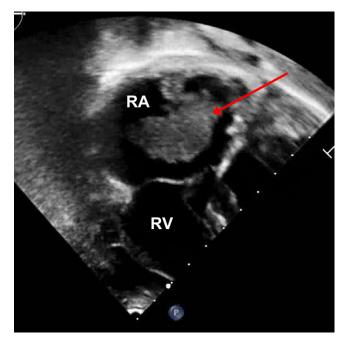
Echocardiogram (apical view) at 3 months post-operative with large right atrial thrombus (red arrow) attached to the atrial septum. RA=right atrium; RV=right ventricle.
